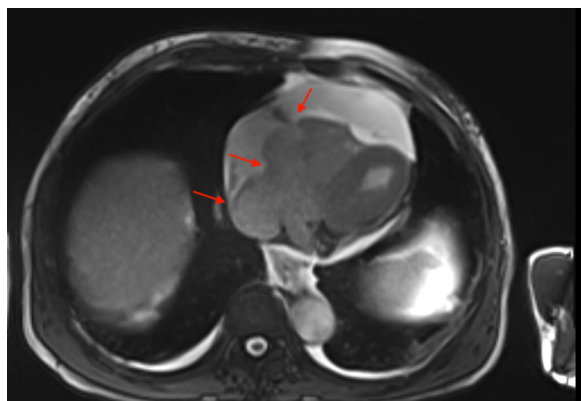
MRI demonstrates giant mass invading myocardium and pericardium (Coronal plane)
